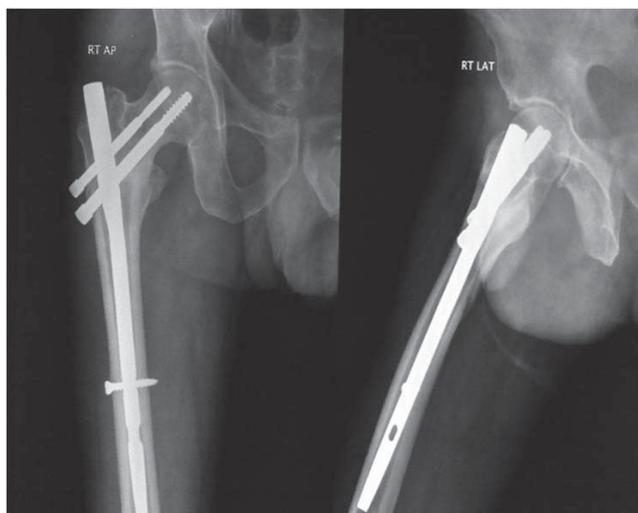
One year post-operative radiographs (antero-posterior and lateral views)
